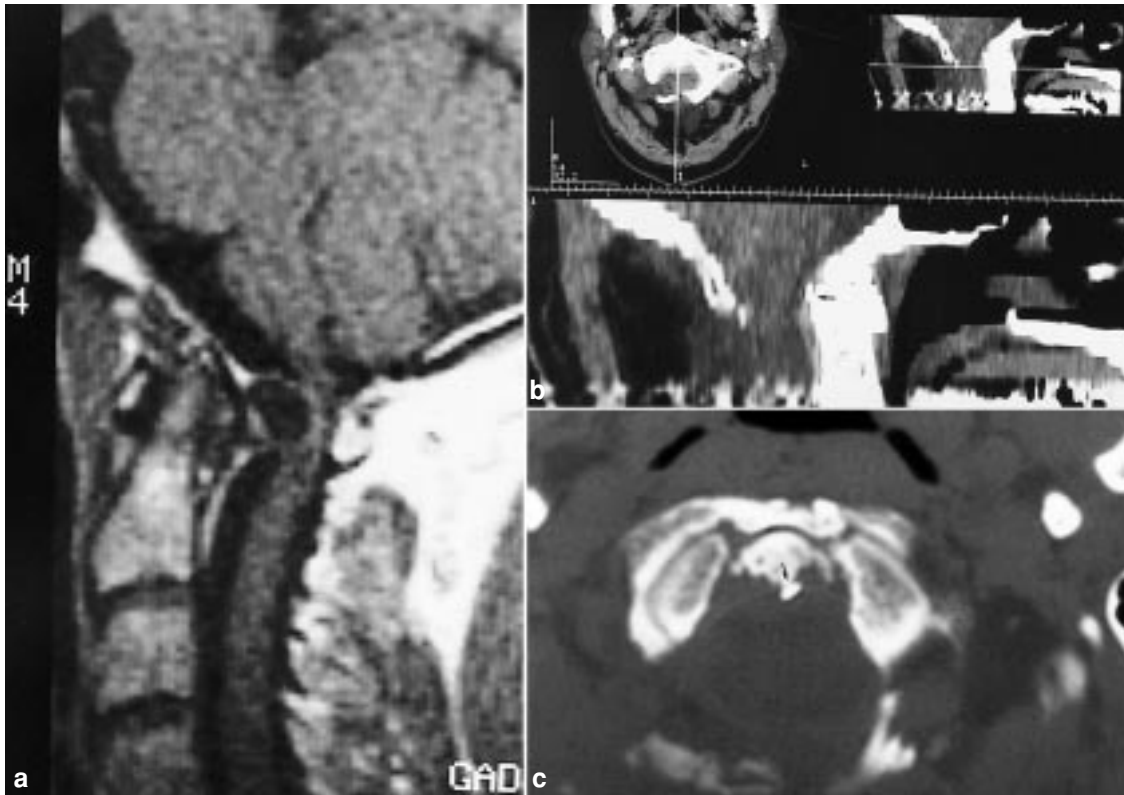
Synovial cyst. (a) Pre-operative MRI (sagittal view). (b) Post-operative CT scanner showing the very limited drilling of the condyle. Notice the clip (arrow) placed on the tip of odontoid for post-operative checking. (c) Post-operative CT scan in coronal view. Notice the clip (arrow)
